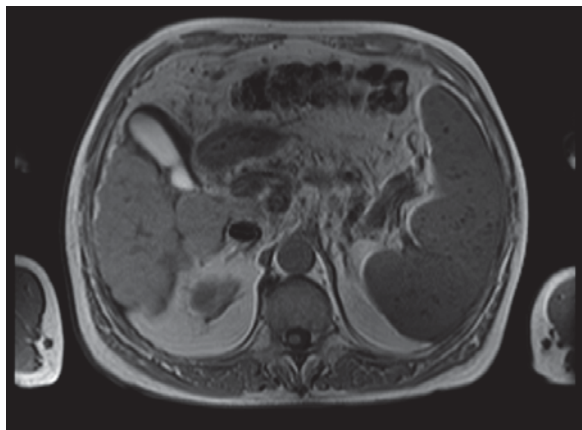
Abdominal magnetic resonance imaging showed splenomegaly.
